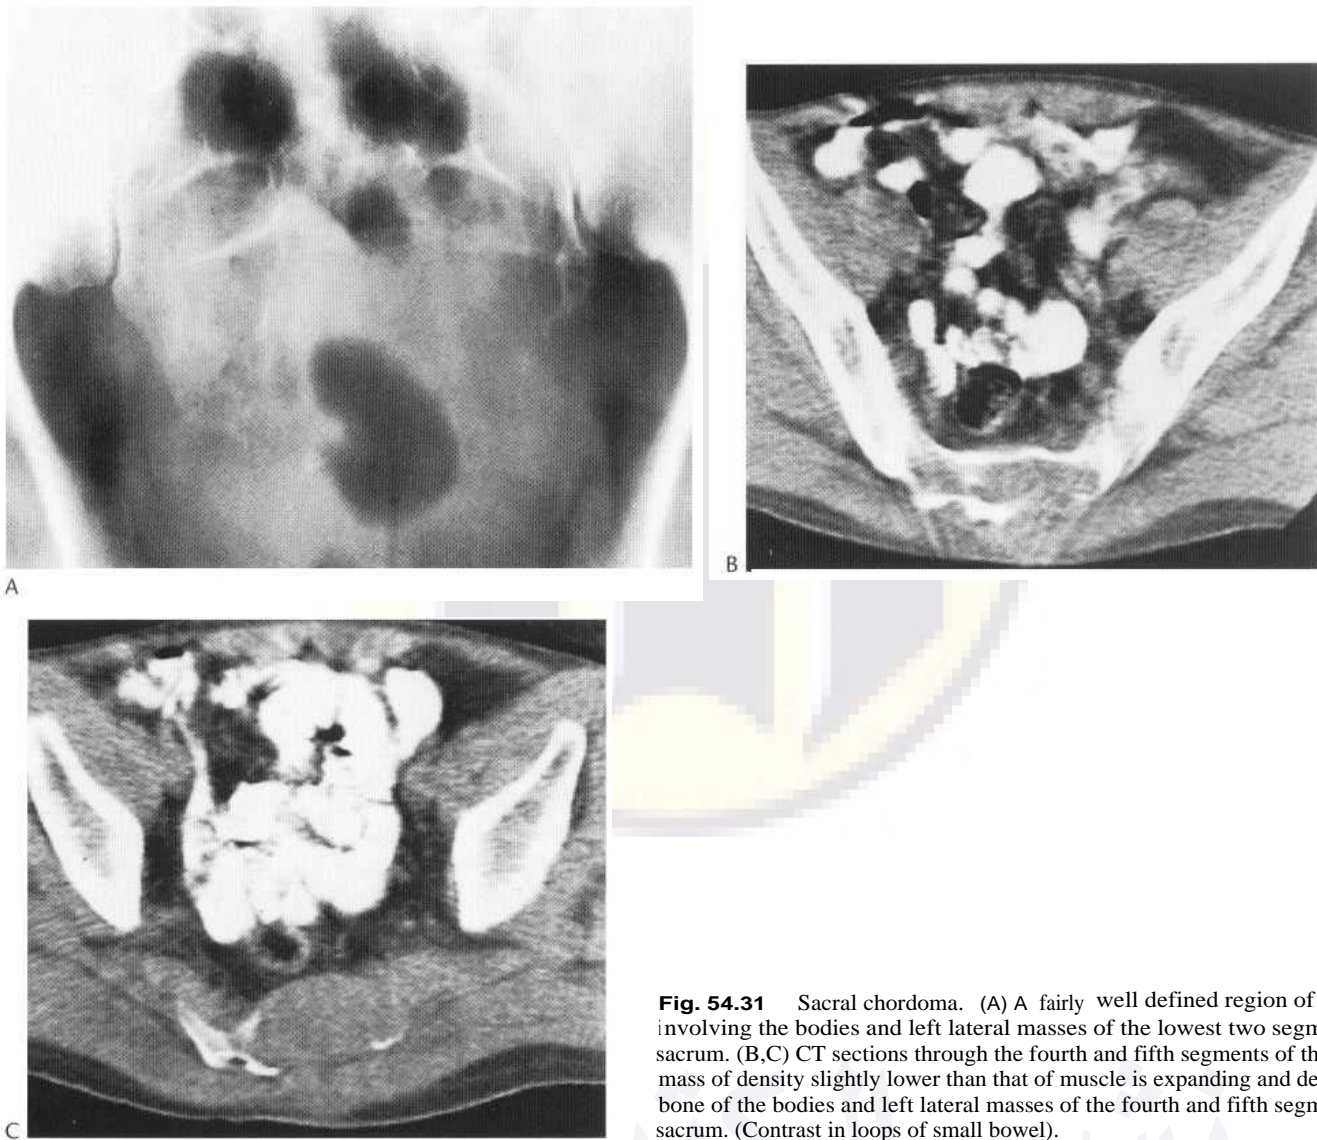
Sacral chordoma. (A) A fairly well defined region of destruction involving the bodies and left lateral masses of the lowest two segments of the sacrum. (B,C) CT sections through the fourth and fifth segments of the sacrum. A mass of density slightly lower than that of muscle is expanding and destroying the bone of the bodies and left lateral masses of the fourth and fifth segments of the sacrum. (Contrast in loops of small bowel).
